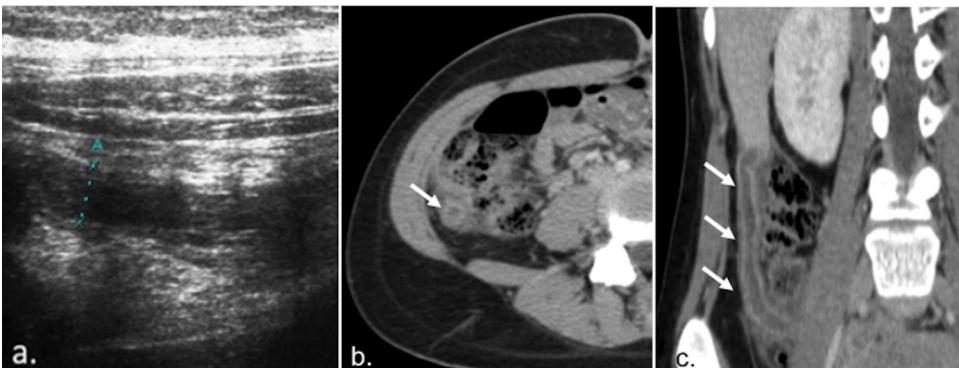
Accessory ovarian vein thrombosis in a 15-year-old puerperal woman with fever and pain in her right flank, with clinical suspicion of acute appendicitis. Ultrasound (a) shows a hypoechoic tubular structure in the right iliac fossa diagnosed as appendicitis. Computed tomography (b–c) revealed bilaterally thrombosed ovarian veins (arrows) with a retrocaecal path on her right flank.
